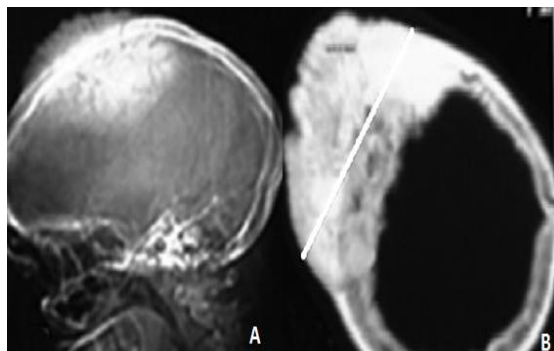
a: X ray lateral plan. Figure 1 b: CT scan head. (Showing right parietal hyperdense area)
